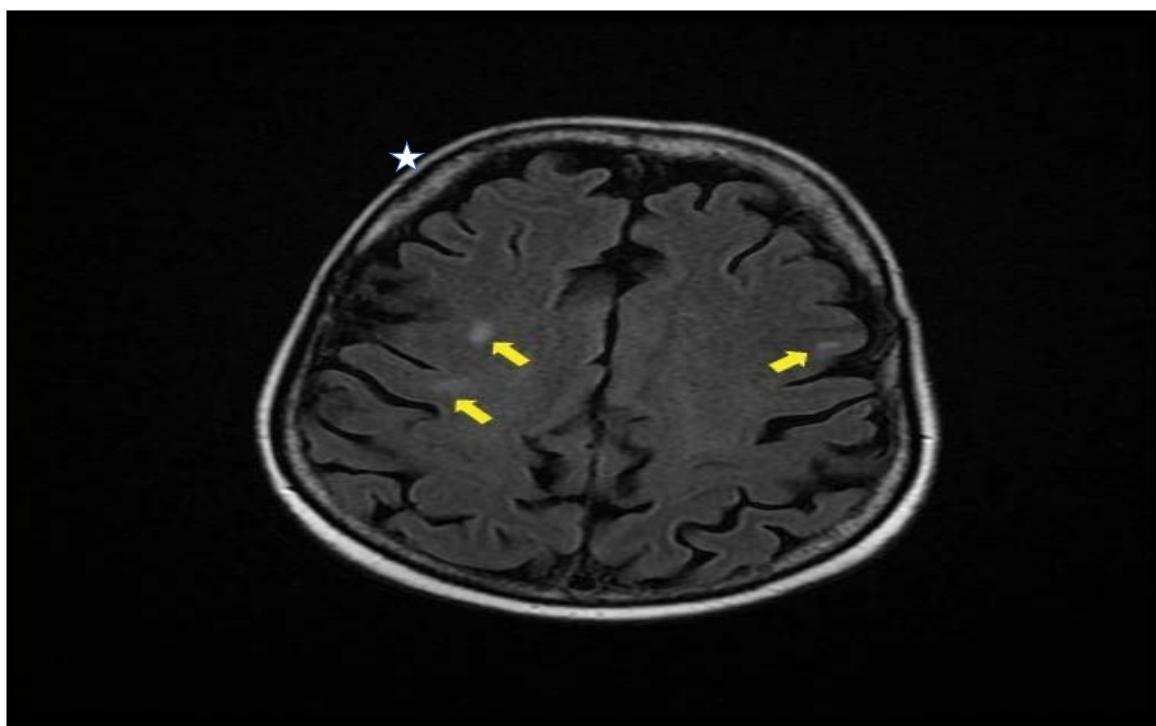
Brain MRI showing no brain metastasis but revealing multiple focal hyperintense lesions in the subcortical white matter (arrows).
